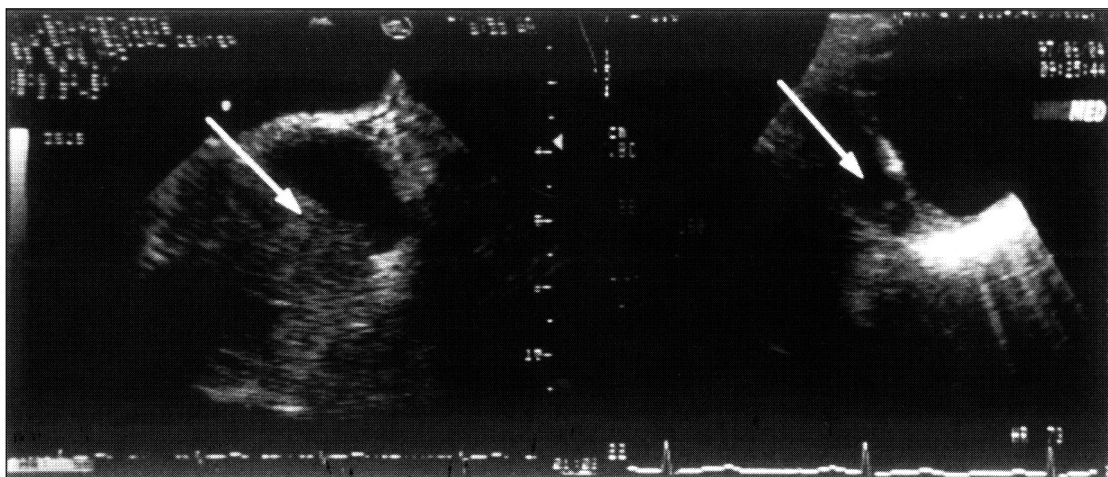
Transesophageal echocardiography at the level of ascending aorta in patient with type A aortic dissection shows small true lumen and large false lumen filled with thrombi(left arrow) and decreased false lumen with the thrombi resolved(right arrow) in 6 years.
